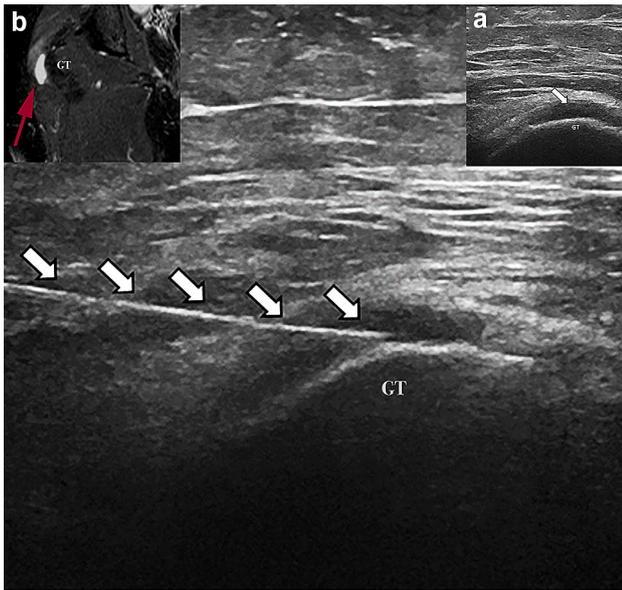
US-guided CSI image. Injection needle (pointed by white wide arrows) is seen reaching great trochanter (GT). Upper right US image (a) where a trochanteric bursa inflammation is identified. Upper left MRI image (b) with a trochanteric bursa inflammation (red arrow)
